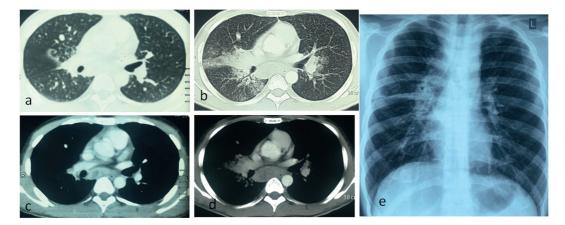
a) HRCT thorax showing few bilateral centrilobular nodules b) follow up CT (after 1 month) showing increase in parenchymal nodules along with a new consolidation with collapse involving right middle lobe medial segment c) CECT mediastinal window showing enlarged subcarinal lymph node at baseline d) CT (after 1 month) showing increase in the lymph node size e) follow up x-ray chest showing significant improvement in the parenchymal nodules and consolidation.
